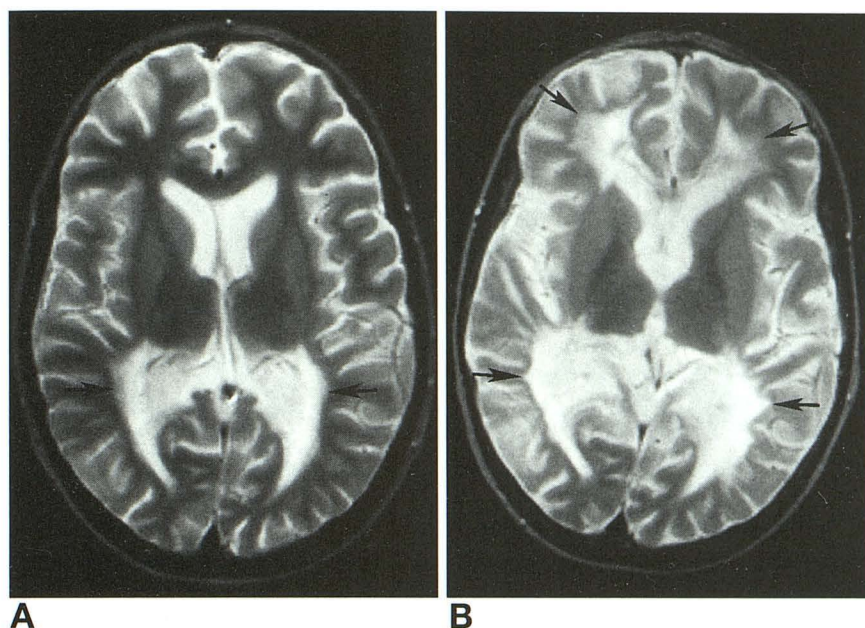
Serial axial T2-weighted MR images (2500/90) obtained 1 month before (A) and 18 months after (B) transplantation (patient 3) show significant central-to-peripheral and posterior-to-frontal progression (arrows).
